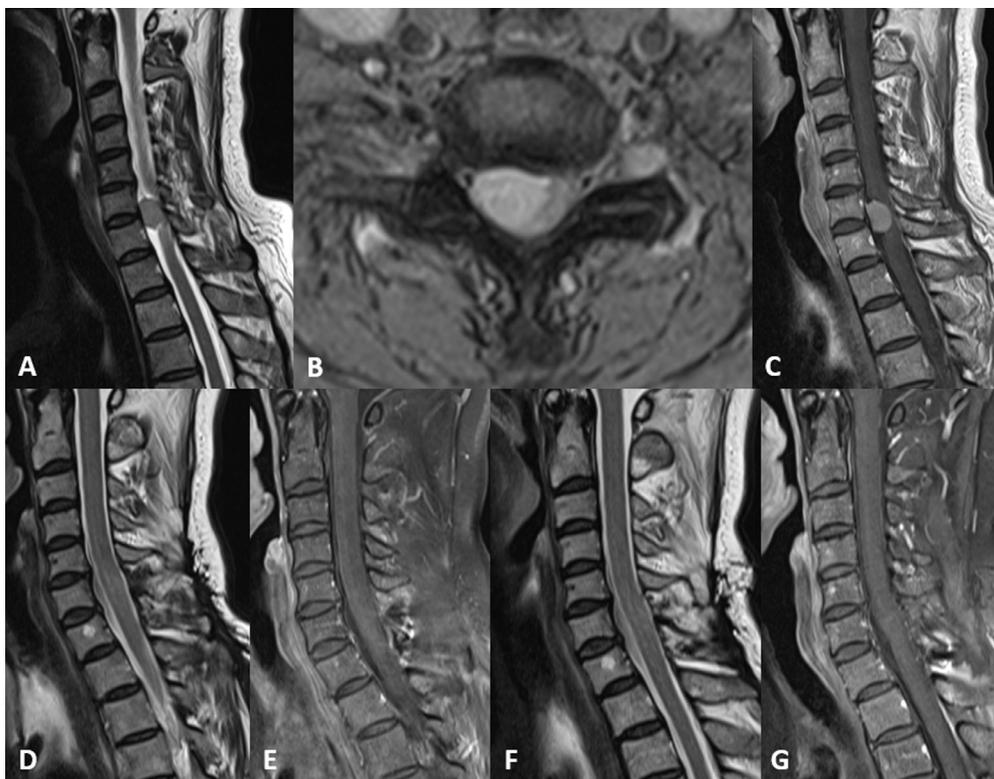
A patient with primary atypical spinal meningioma who underwent complete tumor resection. A spinal tumor at C6-7 was found using MRI (A–C). The tumor was located in the ventrolateral region and was excised completely (D and E). Follow-up MRI 5 years later showed no recurrence (F and G). MRI, magnetic resonance imaging.
